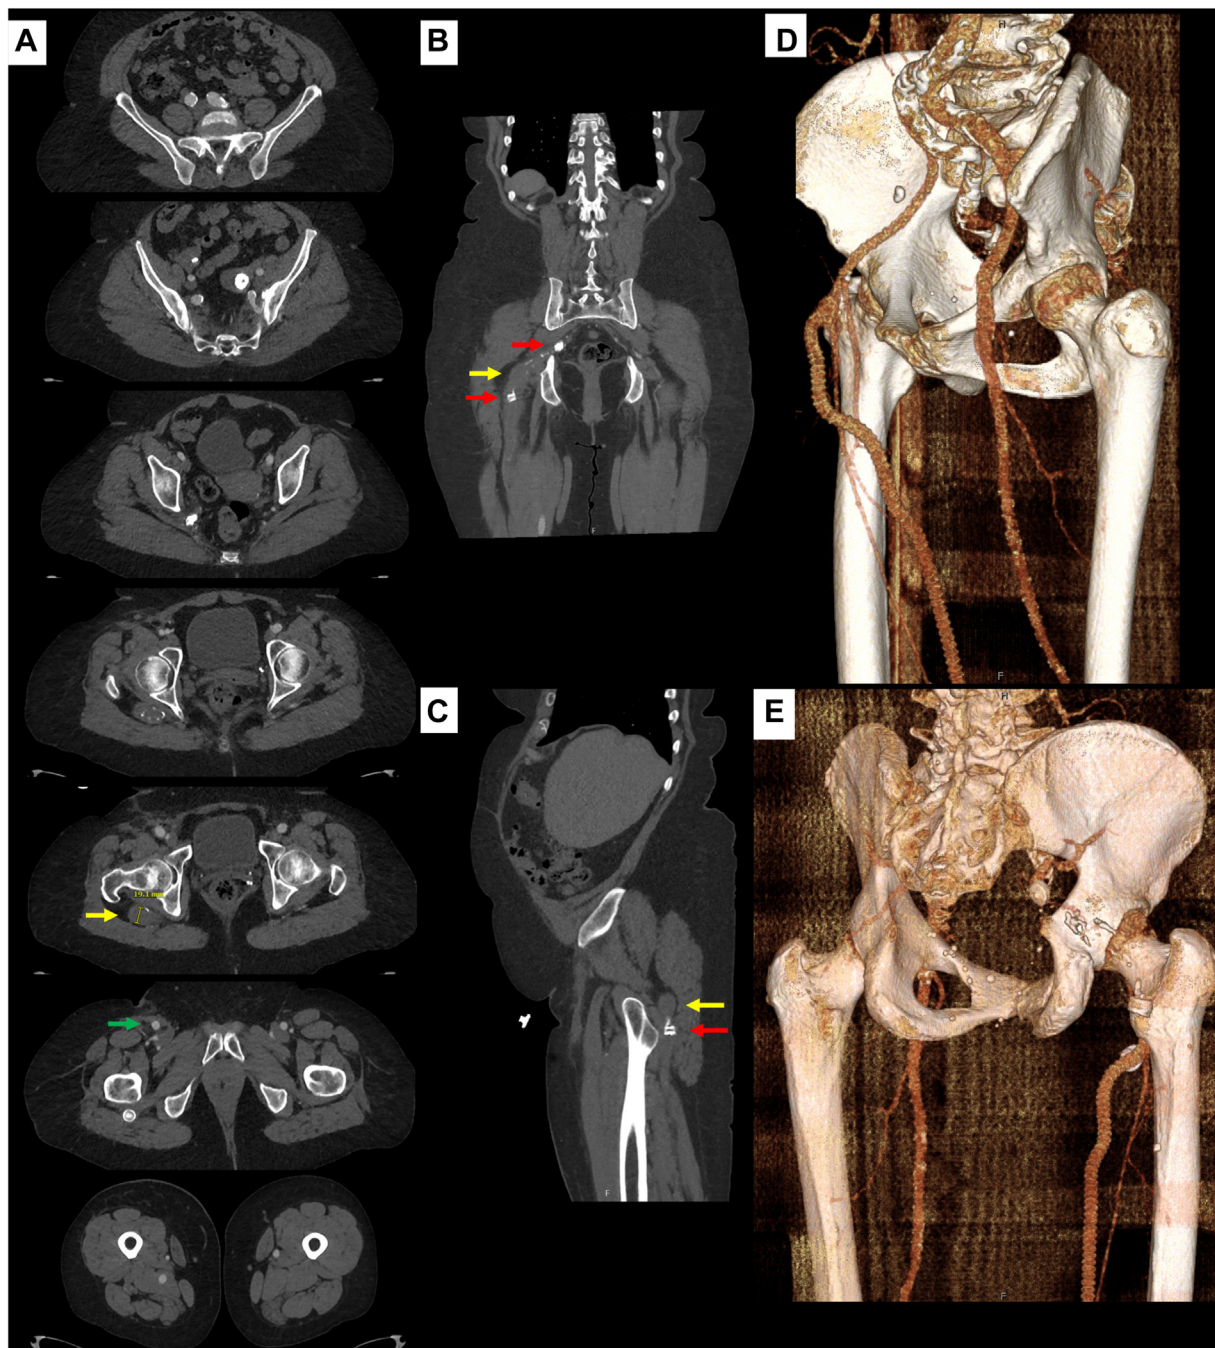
Computed tomography angiogram (CTA) of the abdomen and pelvis from the 3-month follow-up showing successful exclusion of the right persistent sciatic artery (PSA) fusiform aneurysm (yellow arrows) and two Amplatzer plugs (red arrows) located proximally and distally to the excluded sciatic artery aneurysm, with a patent common femoral artery (CFA) to below-knee popliteal polytetrafluoroethylene bypass (green arrow). A, Axial views of multiple cross-sectional levels showing excluded sciatic artery fusiform aneurysm measuring 1.9 cm in maximal diameter. B, Coronal view. C, Sagittal view. D, Three-dimensional reconstruction of left anterior oblique view. E, Three-dimensional reconstruction of posterior view.
